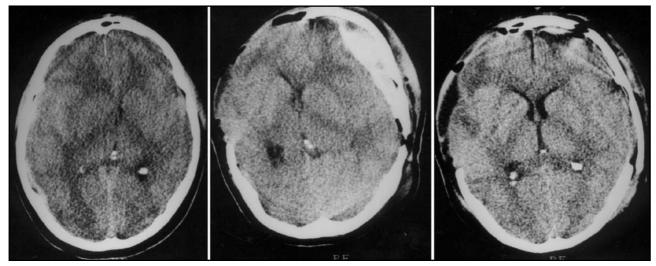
Serial noncontrast CT scans of patient 2. A, initial CT scan showing predominantly hemispheric swelling and midline shift. The patient was comatose and there were clinical signs of transtentorial herniation. B, the next day, the patient developed an uncal pupil on the left. CT scan demonstrated a large subdural hematoma of delayed onset. C, CT scan at a late stage.
